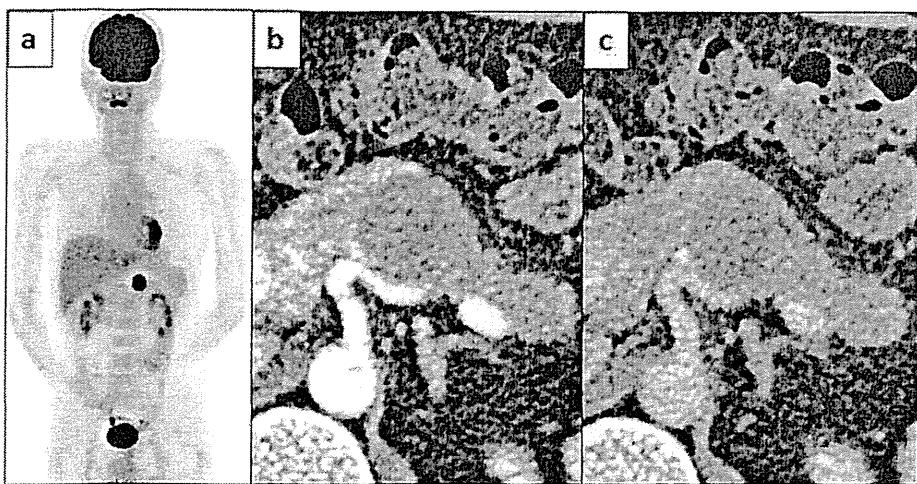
Preoperative images. *a*: Significant fluorodeoxyglucose accumulation with a maximum standardized uptake value of 10.6 was detected in the pancreatic body on positron emission tomography. No other significant accumulation was seen. *b*: Computed tomography (CT) of early enhanced phase. *c*: CT of late enhanced phase. The tumor was located in the pancreatic body, 33×31 mm, and was oval with a clear boundary, without calcification inside. Enhancement study showed prolonged enhancement of the tumor. No main pancreatic duct dilatation was observed.
